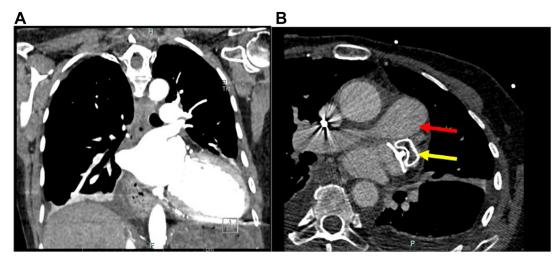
Cardiac computed tomography angiograms post pericardial window. A: Coronal view. No significant pericardial effusion. B: Transverse view. No erosion of left atrial appendage occlusion device (*yellow arrow*) in pulmonary artery (*red arrow*).
